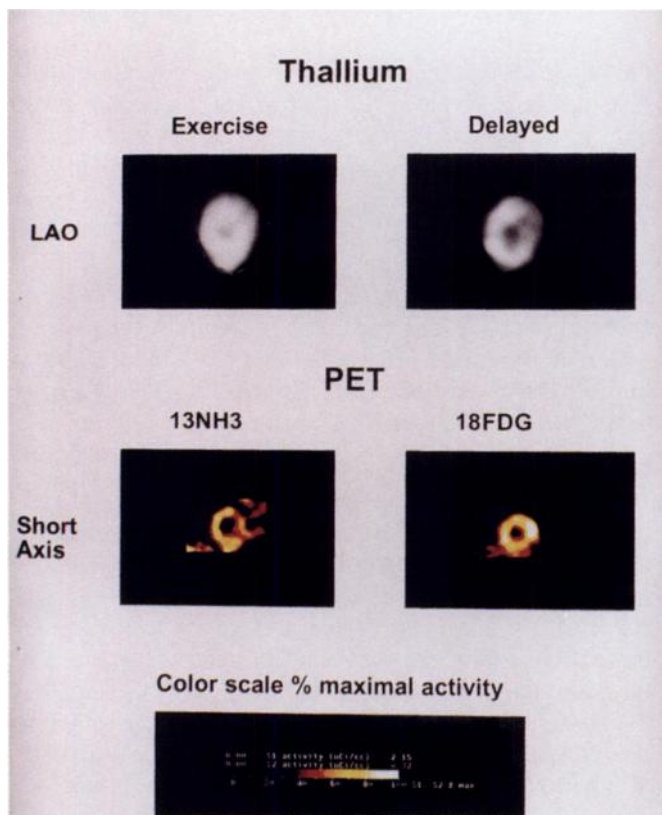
Study of a 71-yr-old white male with an infero lateral MI in 1991, who was referred after adjustment of his medical therapy. The thallium left anterior oblique view images (upper panel) are representative of short axis left anterior oblique ^{13}N -ammonia flow and ^{18}F FDG studies are also shown (lower panel). The lateral wall on the thallium left anterior oblique view reveals a defect on the 2.5 hr delayed images. The corresponding PET images below show decreased perfusion of the lateral wall on the ^{13}N -ammonia image with augmented ^{18}F FDG in the corresponding segment. The lateral wall is considered viable (ischemic) in this example.
